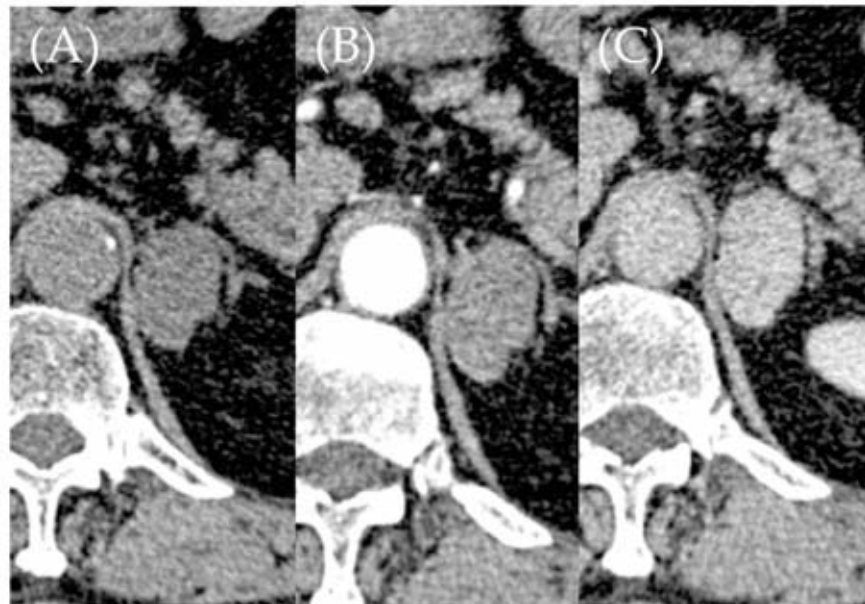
Computed tomography (CT) revealing a solid, well-defined edge and a homogeneous mass in the left adrenal gland. A) Unenhanced CT scan showing left adrenal mass (22 HU); B) enhanced CT scan showing left adrenal mass (111 HU); C) delayed enhanced CT scan showing left adrenal mass (29 HU). Enhancement washout = 82 HU (111-29 HU); enhancement = 89 HU (111-22 HU); percentage enhancement washout = 92% [(enhancement washout/enhancement) = (82/89) × 100].
